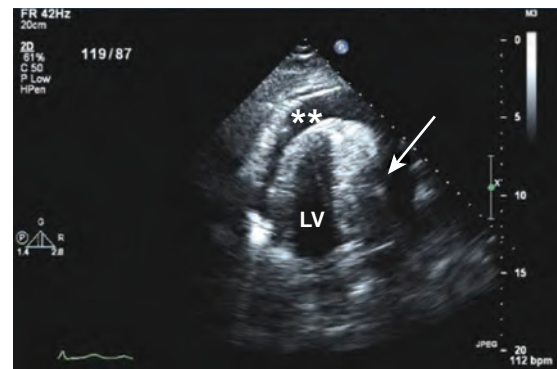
Transthoracic echocardiogram in parasternal four-chamber view. A large echolucency in the pericardium (double asterisks) indicates a large pericardial effusion. The right side of the heart completely collapses in diastole (arrow), indicating hemodynamically significant physiologic tamponade. LV, Left ventricle.
